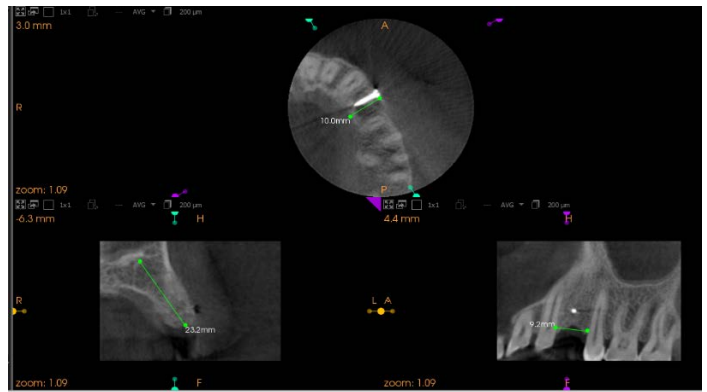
Postoperative view-after 8 months CBCT
